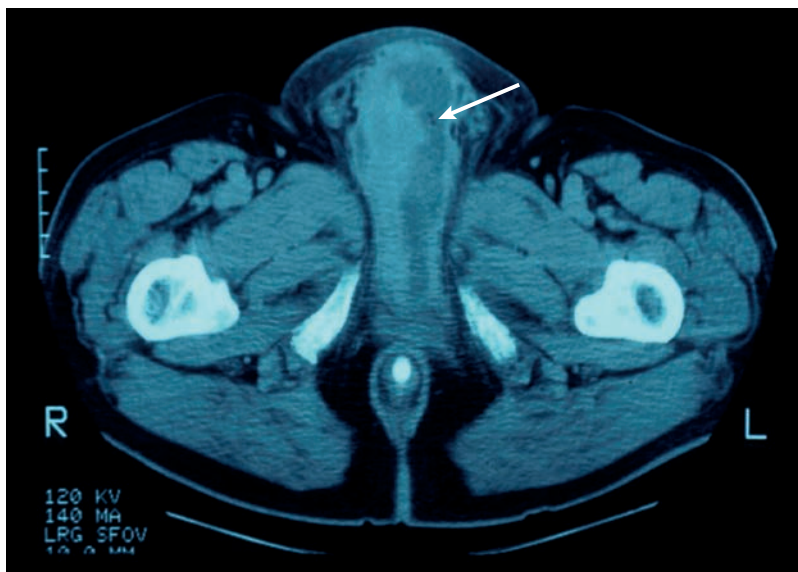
Pelvic CT scan of a patient with Fournier's gangrene. This axial view shows a fluid-filled pocket, and gas in the scrotum and tracking into the perineum, which is indicative of a necrotizing soft tissue infection with a possible anaerobic, gas-forming organisms (white arrow: foci of gas).
